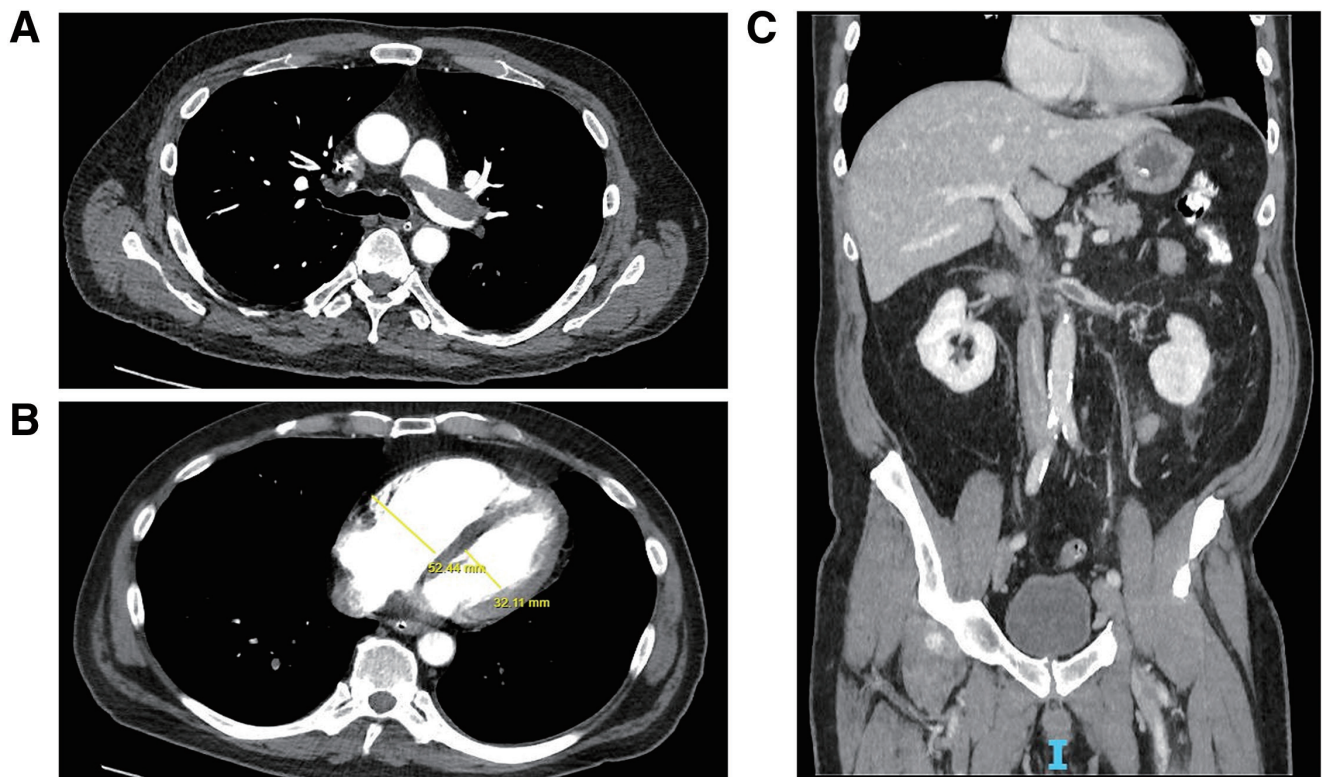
(A) Saddle and bilateral PE seen on computed tomography pulmonary angiography. (B) Right ventricular dilatation as evident by RV/LV ratio of more than 1. (C) Severe stenosis of the supra-renal IVC with thrombus seen in the left renal vein and IVC. IVC: inferior vena cava; PE: pulmonary emboli; RV/LV: right ventricular/left ventricular
